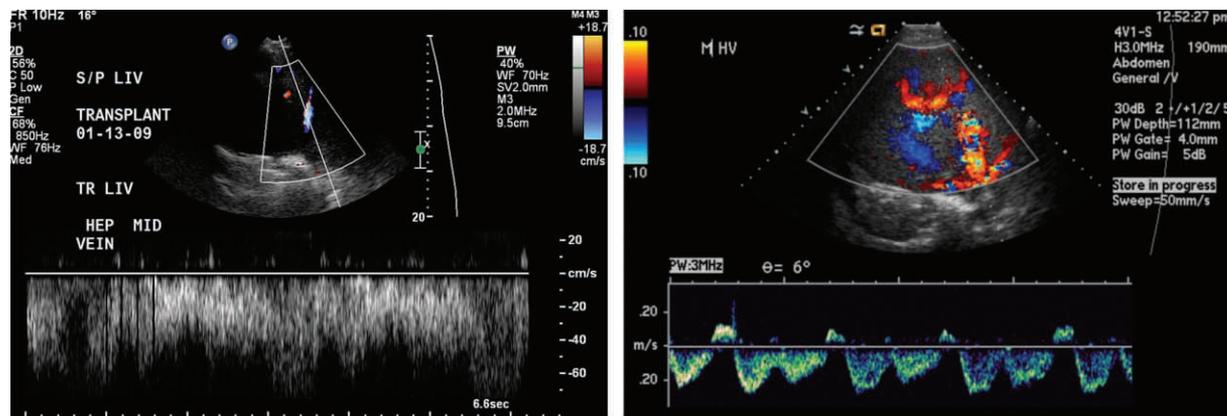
Transient dampening of the hepatic vein waveform in a 51-year-old man after orthotopic liver transplantation. (a) Duplex Doppler image obtained 1 day after surgery shows the waveform of the middle hepatic vein. The spectrum is in the correct direction, posteriorly toward the IVC; however, the waveform is blunted. The patient continued to do well clinically. (b) Duplex Doppler image obtained 1 day later shows a normal waveform of the middle hepatic vein.
